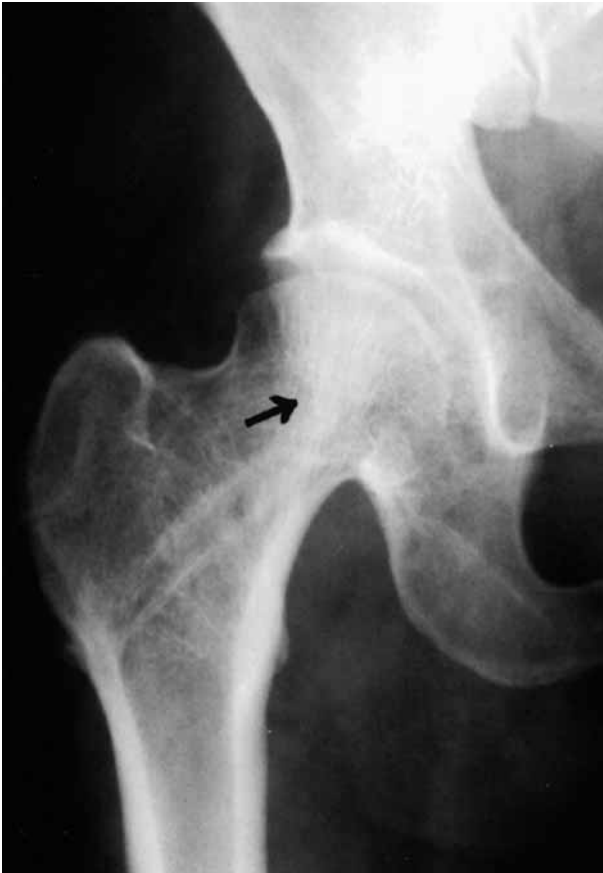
Radiograph of hip (AP view) showing less than $\frac{1}{2}$ incorporation of the fibular graft, but trabeculae are seen to cross the fibular graft as well as the fracture site.
